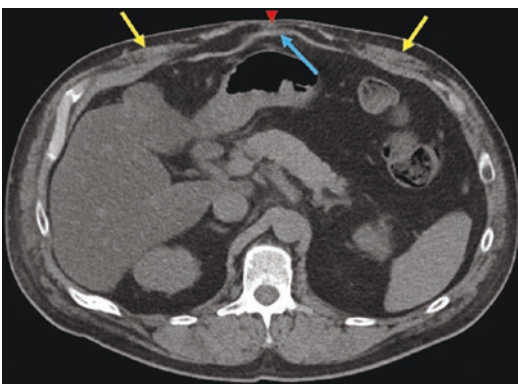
CT abdomen showing significant splaying of the rectus abdominis muscles (yellow arrows), an attenuated linea alba (red arrow), and an intra-peritoneal inlay mesh (blue arrow). In this case, a biologic mesh was used and is visible on this CT scan performed 1 year postoperatively
